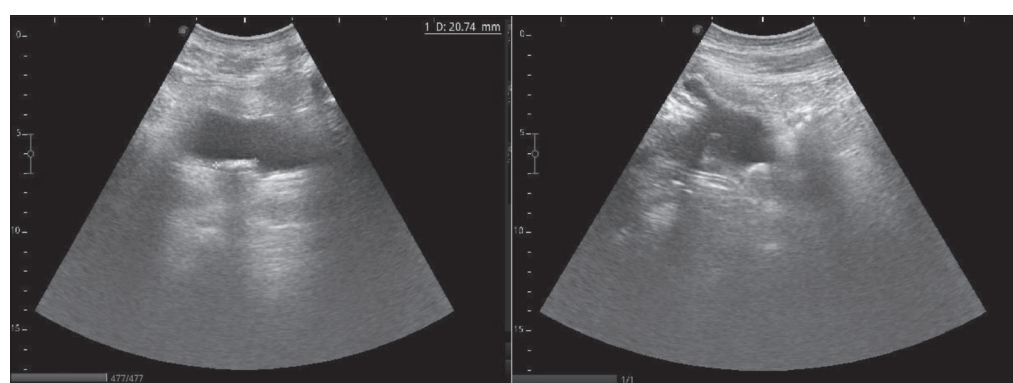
Ultrasound image of the bladder with hyperechoic structure inside
